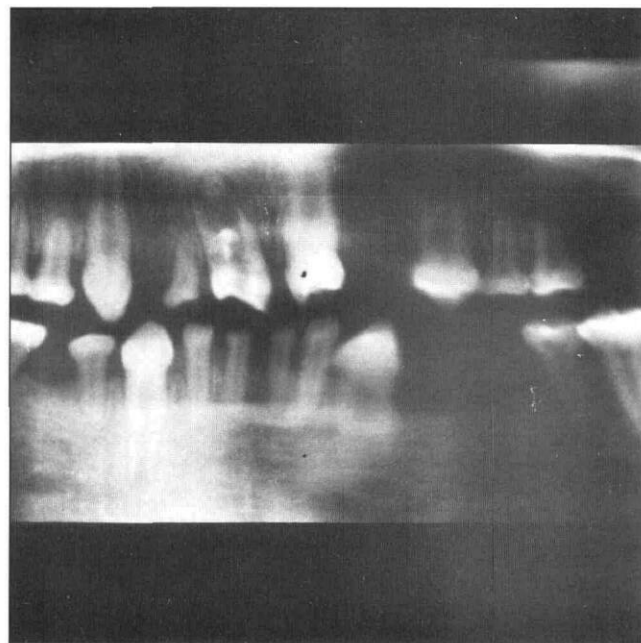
Panoramic radiograph of Case 1. Notice the single-rooted primary and permanent molars and the multiple missing teeth.
